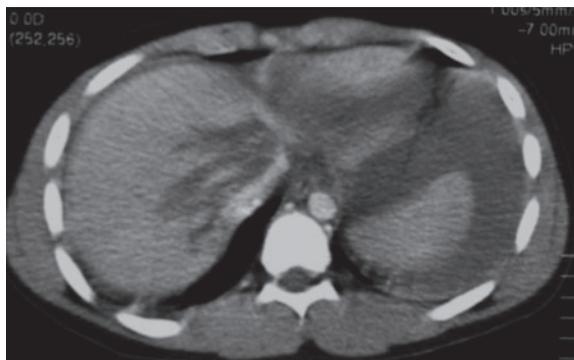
Contrast-enhanced CT scan – a stellate fracture of the right superior segments of the liver with extension into the hepatic veins; "bear claw" lacerations.
